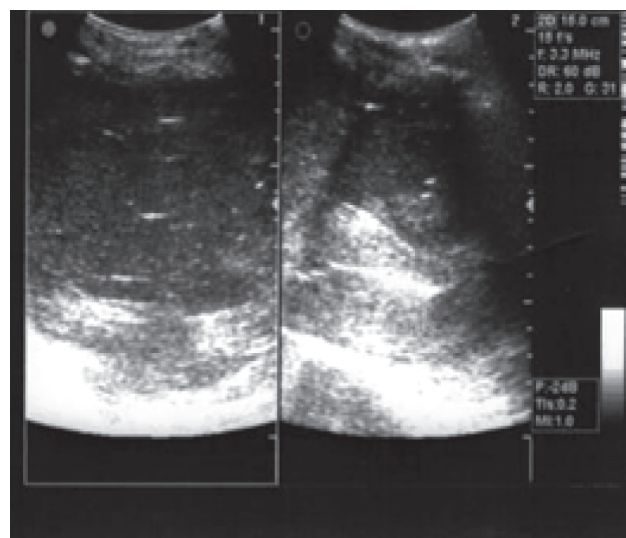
Ultrasound of the pelvis showing large cystic mass with fluid -fluid level. Linear echogenic structure representing hair noted within it.
